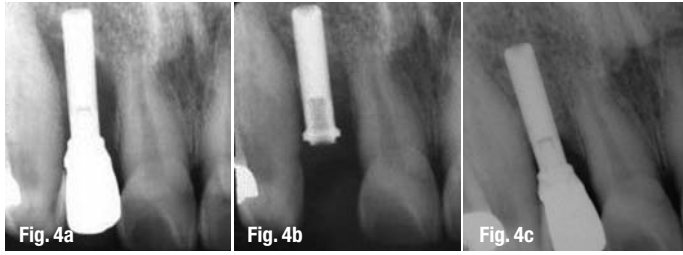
The periapical radiograph revealed peri-implantitis with bone loss of > 5 mm (a). The abutment was removed and surgical treatment using the LiteTouch laser was performed. Bone grafting with a biomembrane followed the laser treatment (b). The periapical radiograph revealed bone regeneration after six months (c).
